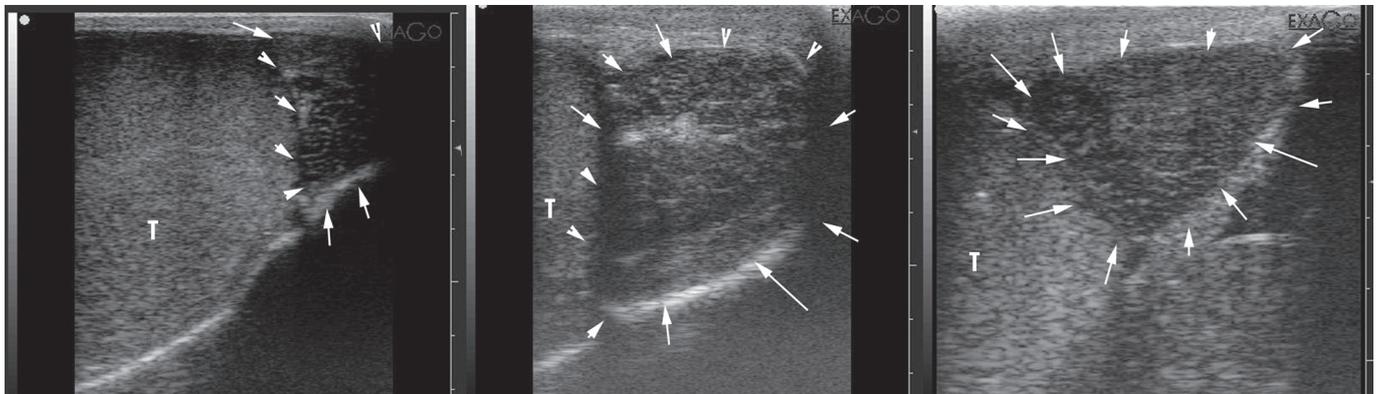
Normal ultrasonogram of the tail of the epididymis (arrows delineate the tail of the epididymis, T= testicular parenchyma)
